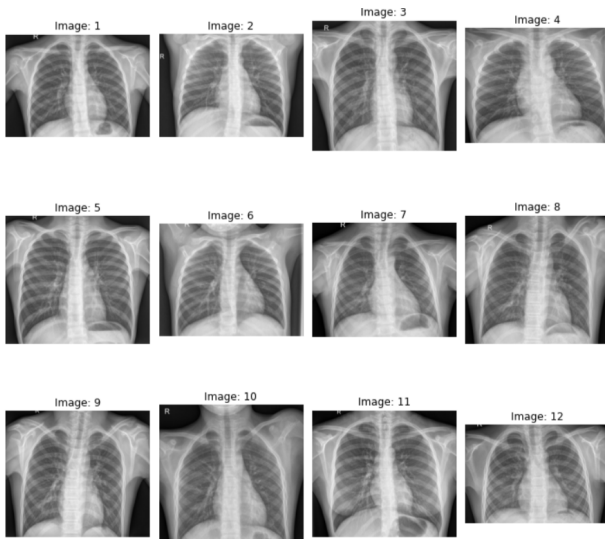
Example Images from Chest X-Ray Pneumonia Dataset
